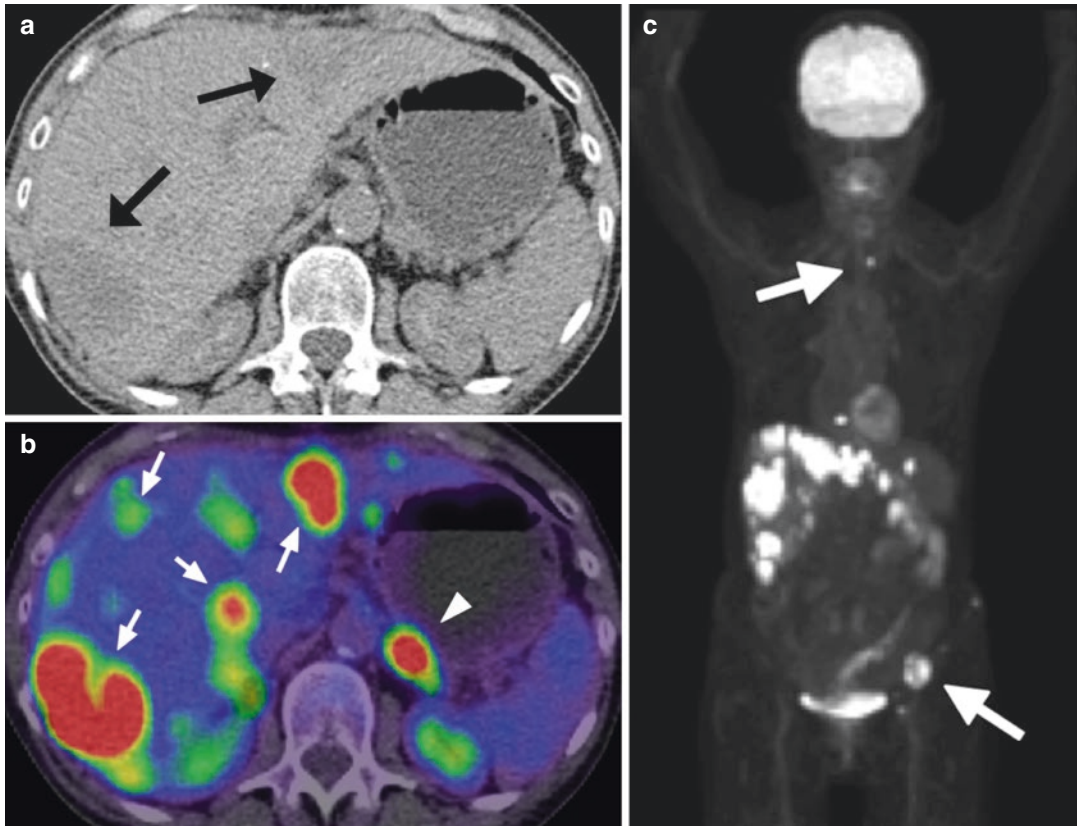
Multiple CLMs (arrows) hypodense to surrounding liver in unenhanced CT (a). FDG-PET-CT (b) better demonstrates the true extent of disease due to strong lesion uptake, including disseminated liver metastasis
